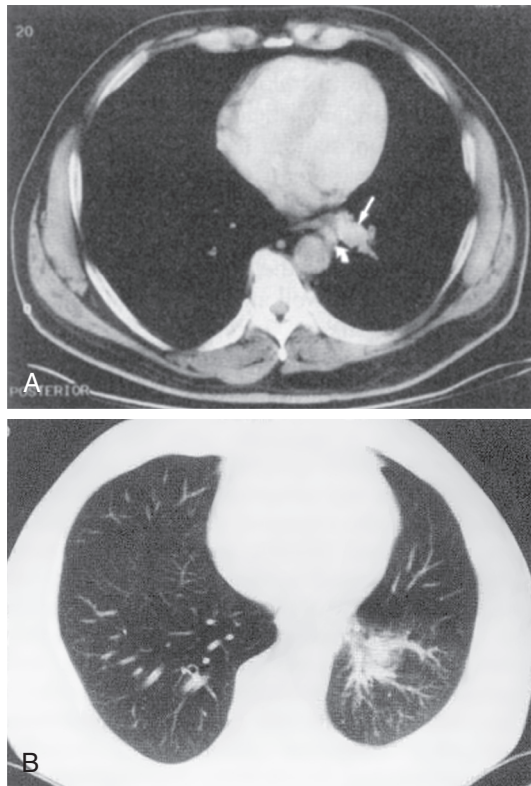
■ Extralobar sequestration. Extralobar sequestration is most frequently found in the lower left chest with its own pleural investment and systemic venous drainage. Computed tomography scan is beneficial in better identifying the anatomic details of the defect. (From Singh SP, Nath H: A 53-year-old man with hemoptysis. *Chest* 120:298-301, 2001.)
